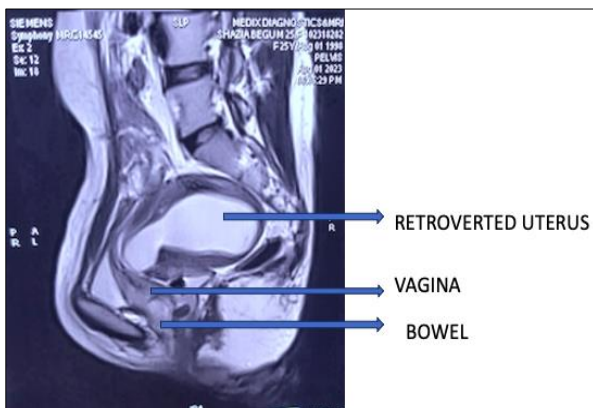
MRI (axial view) showing prolapsed bowel.
